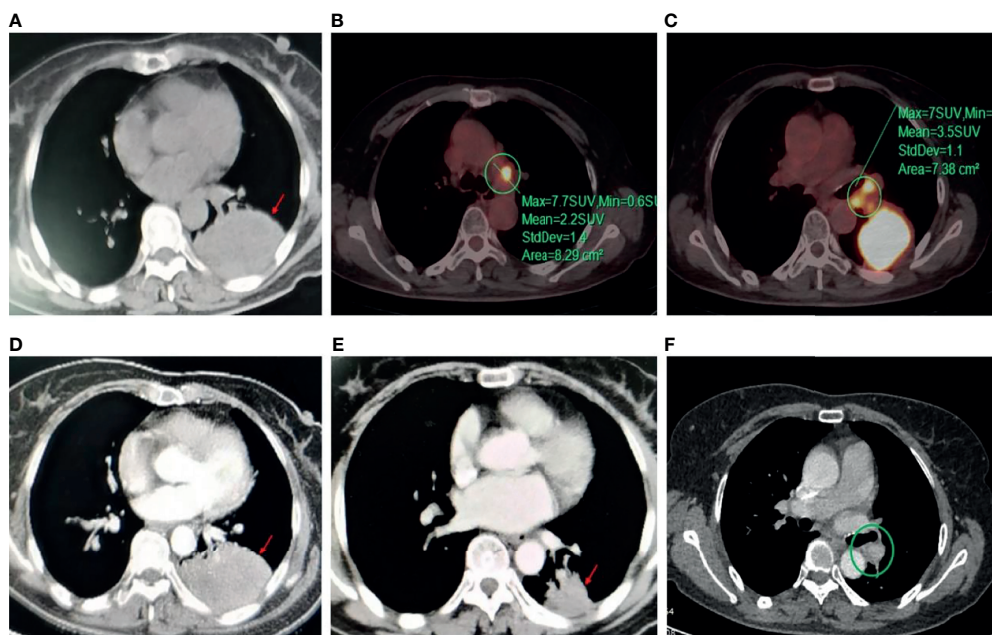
Disease status before and after neoadjuvant chemotherapy and aumolertinib treatment. Computed tomography chest (CT) scan showed that (A) before chemotherapy, the size of the left lower lung soft tissue mass was $10.9 \times 8.9 \times 6.5$ cm. PET/CT showed (B) mediastinal lymph node enlargement before chemotherapy. (C) Multiple lymph node enlargement in the left hilar before chemotherapy. CT scan showed that (D) after 2 cycles of chemotherapy, the disease was judged to be stable based on imaging findings. (E) After 2 cycles of aumolertinib treatment, the size of the left lower lung soft tissue mass was $3.0 \times 4.0 \times 4.0$ cm, and the tumor achieved partial remission. (F) After 2 cycles of aumolertinib treatment, multiple lymph nodes disappeared in the left hilar.
